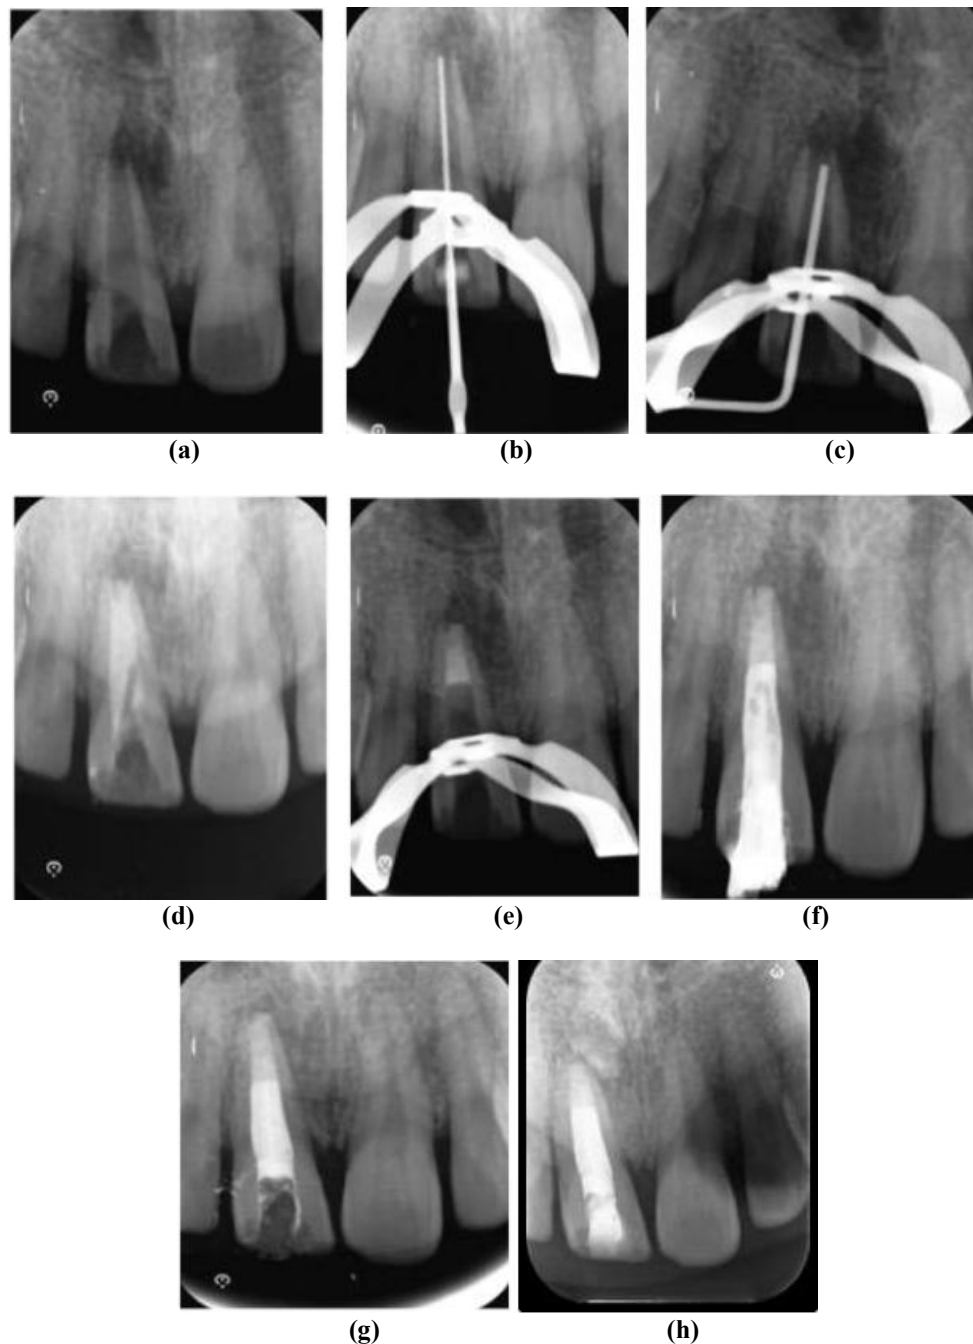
Endodontic treatment stages: a) preoperative status, b) working length determination, c) plugger fit, d) incremental placement of MTA, e) 4 mm apical plug of MTA with clean borders and minimal extrusion, f) Pre-shearing radiograph to check for any lateral space in canal, g) post-operative status (h) 1 year follow up
